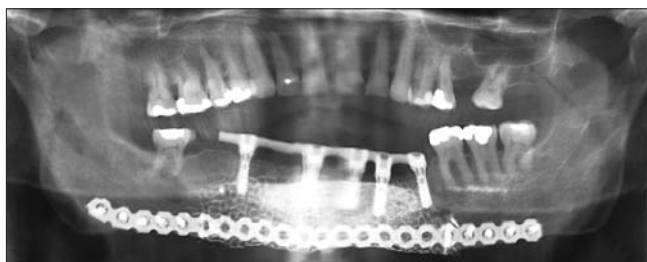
Panoramic radiograph taken 3.0 years after insertion of dental implants into the reconstructed symphysis of Case 1
